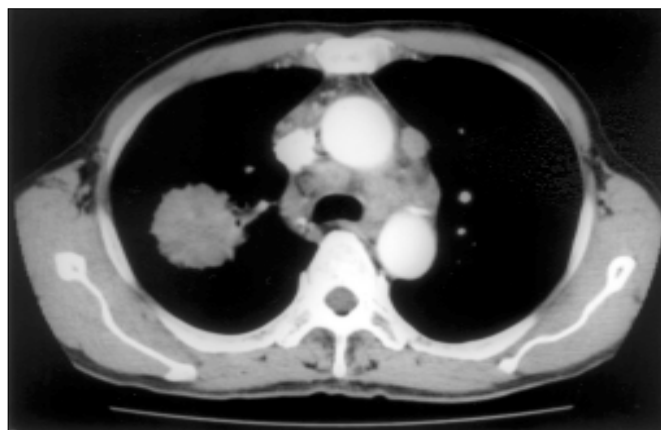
Enhanced CT scan of the thorax (mediastinal window) taken at the level of the carina
